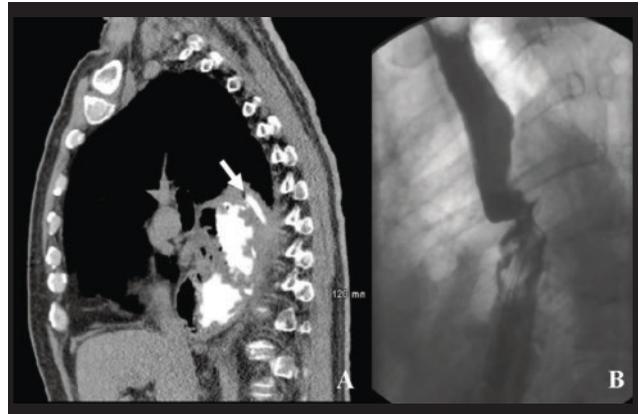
A. CT scan of the thorax revealing a leak of enteric contrast at the level of the esophageal anastomosis with extravasation directed posteriorly into the right chest (white arrow). B. Gastrografin esophagography without evidence of esophageal leak one day following endoclip placement.
